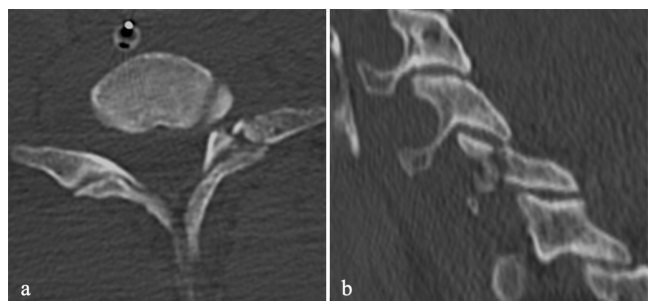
7B. Computed tomography of case 3 shows the seventh cervical vertebral arch fracture. (7A) Axial view. (7B) Sagittal view.
